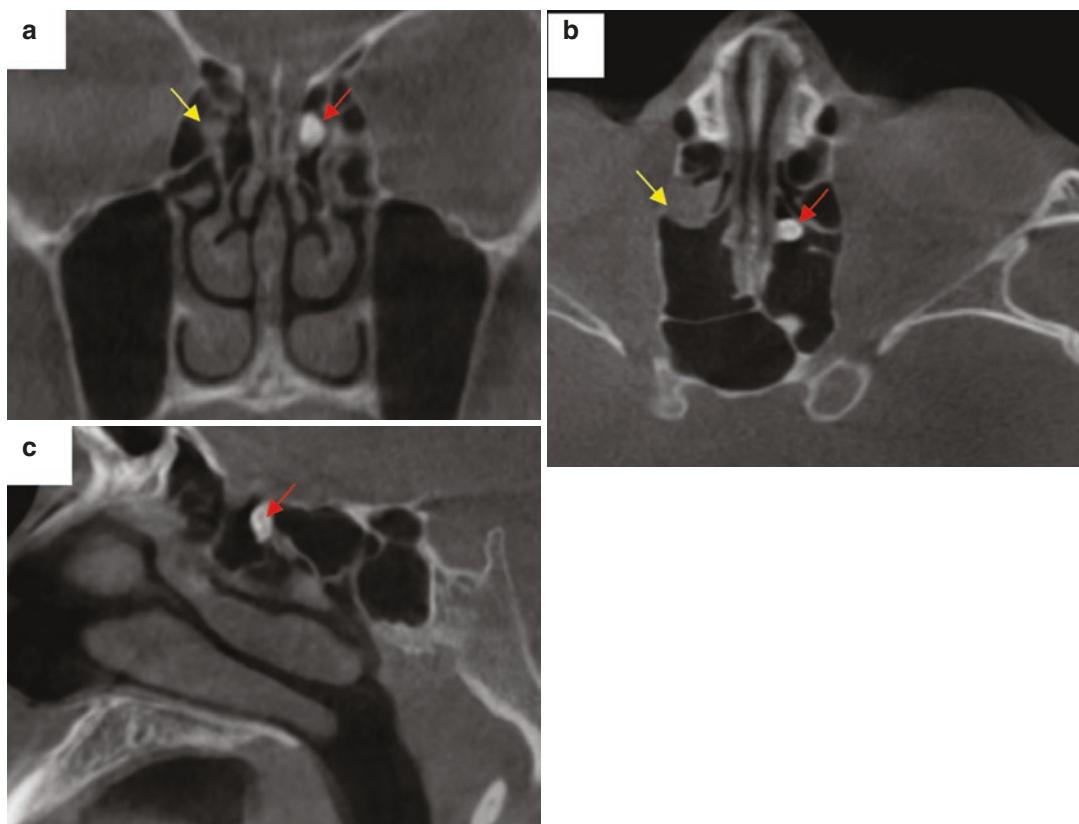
CBCT coronal (a), axial (b), and sagittal (c) images show a well-defined small opacity, possibly an osteoma (red arrows) and mucosal thickening (yellow arrows) within the ethmoid sinuses
